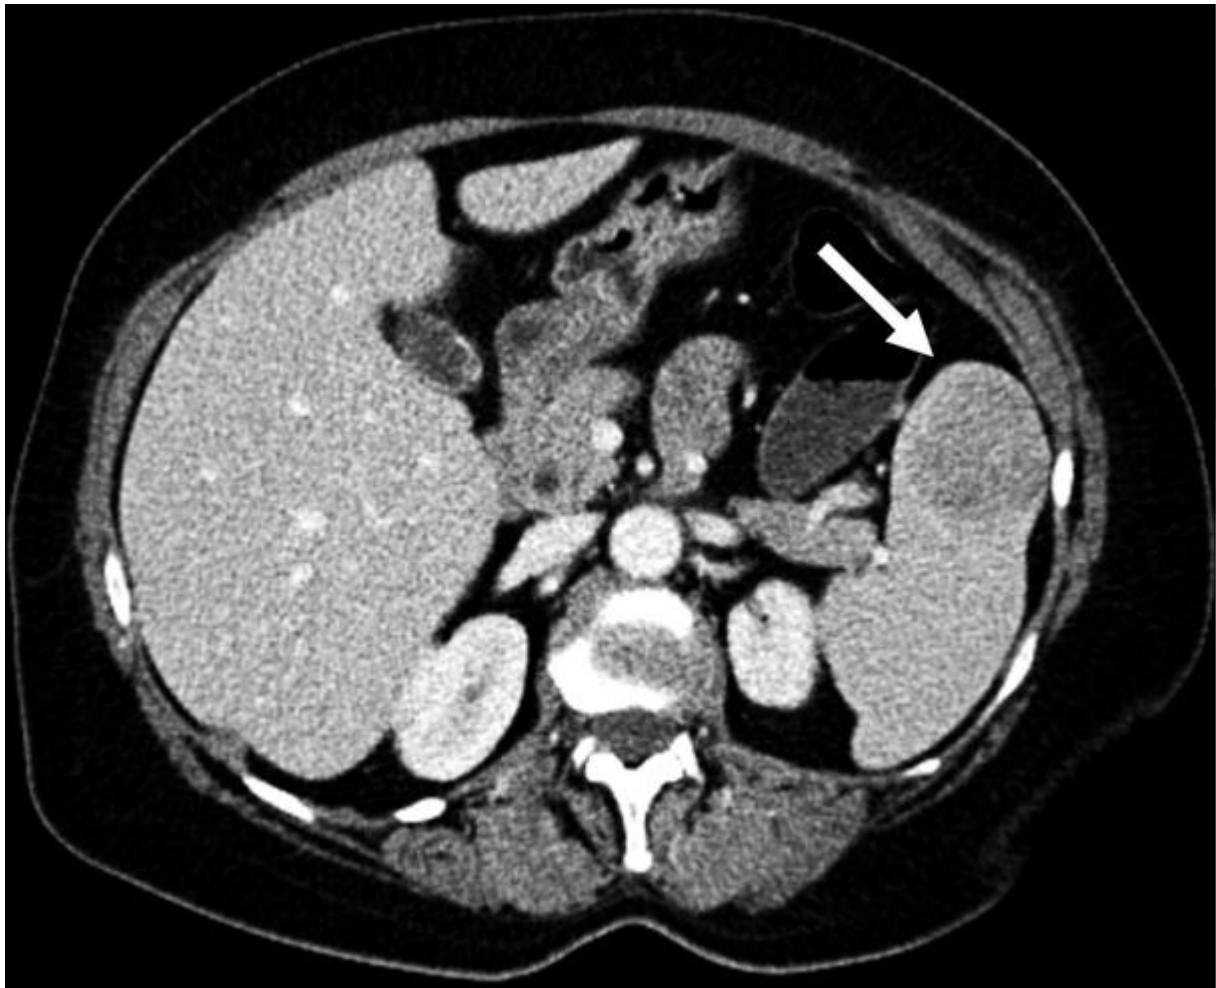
Abdominal CT scan. The arrow points to the change in the upper pole of the spleen
